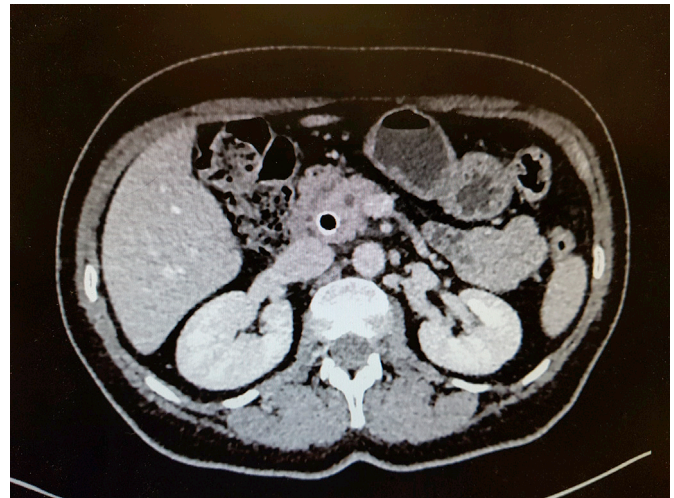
Mass in head of pancreas involving SMV/PV. CT showing an uncinate mass with abutment of PV (Borderline resectable). The patient underwent pancreaticoduodenectomy with *en bloc* PV resection and reconstruction.
